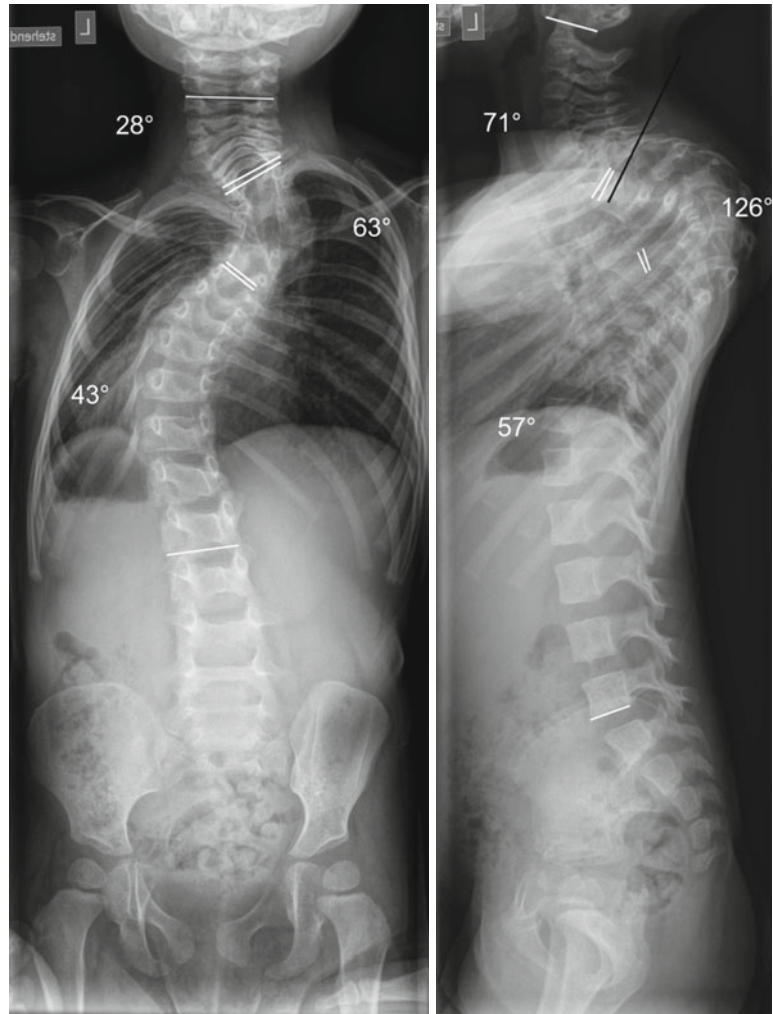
(a) EOS caused by an unknown syndrome. Sitting lateral and posteroanterior radiographs of a girl 9 months of age demonstrate a high thoracic kyphoscoliotic curve pattern. The Cobb angles were as follows: left cervical scoliosis, 25° (C4–T1); right thoracic scoliosis, 41° (T2–T6); left thoracic scoliosis, 6° (T7–T10); cervical lordosis, not measurable on the first X-rays; thoracic kyphosis, 80° (T2–T6); thoracic lordosis, 16° (T7–T12); lumbar kyphosis, 10° (L1–L4) (b). The follow-up shows a rapid deterioration in 15 months time. The lying radiographs demonstrate a thoracic kyphosis of 136° (T2–T7)
